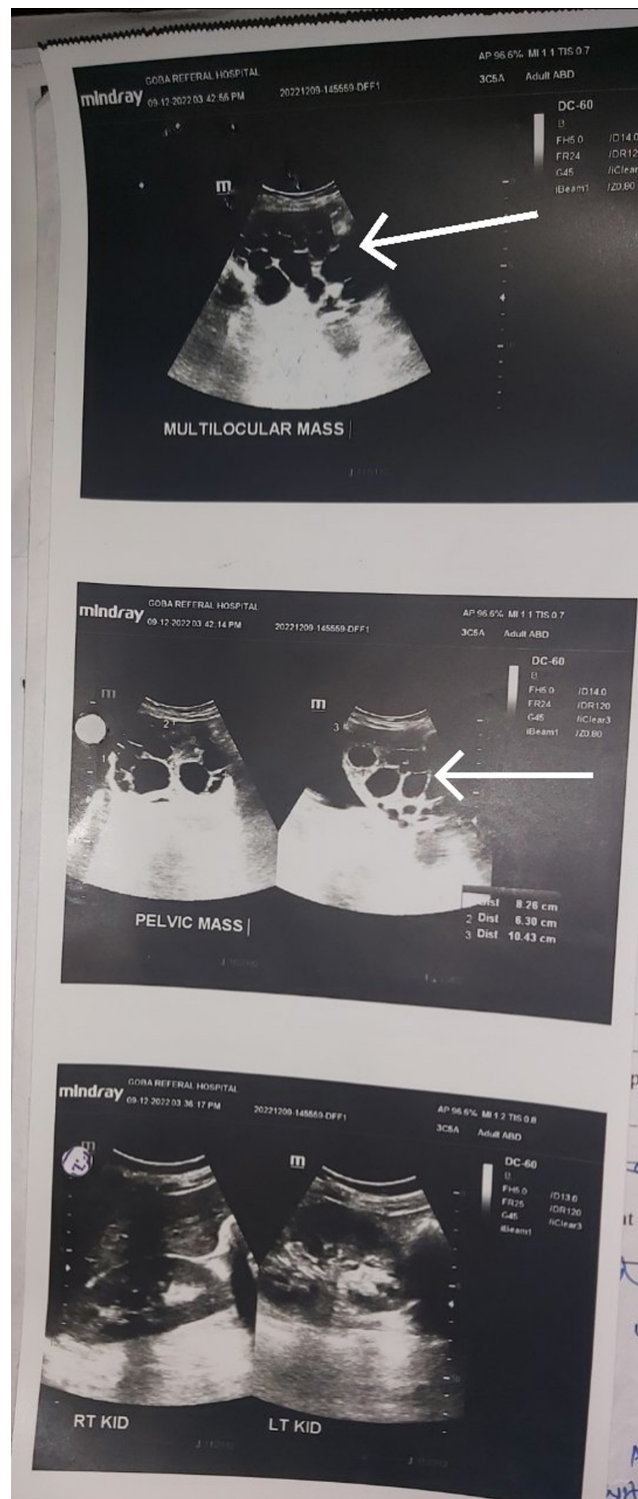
A sonographic image showing multiple daughter cysts (see white arrows).
